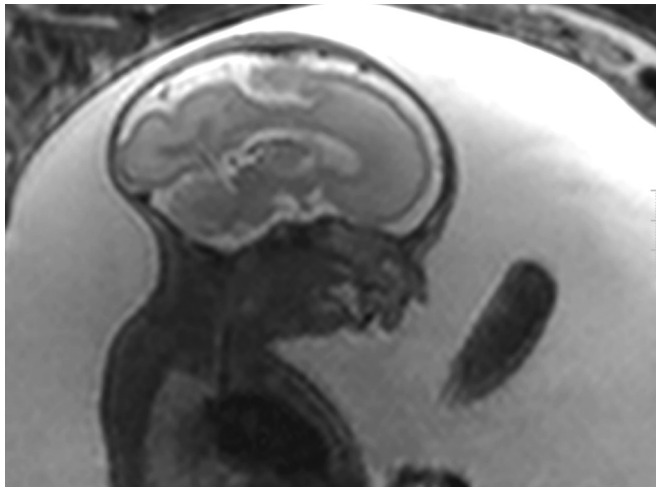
T2 fetal MRI oriented to provide sagittal reconstruction of a fetus with severe micrognathia.
